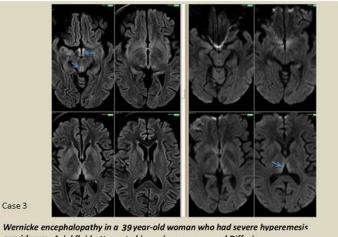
MRI findings in Wernicke's encephalopathy
